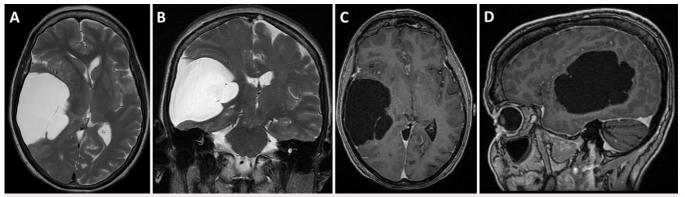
2022 preoperative axial (A) and coronal (B) T2-weighted MRI and axial (C) and sagittal (D) T1-weighted MRI with gadolinium contrast demonstrating a right temporal arachnoid cyst measuring $7.4 \times 5.5 \times 5.8$ cm with 13 mm of leftward MLS.
